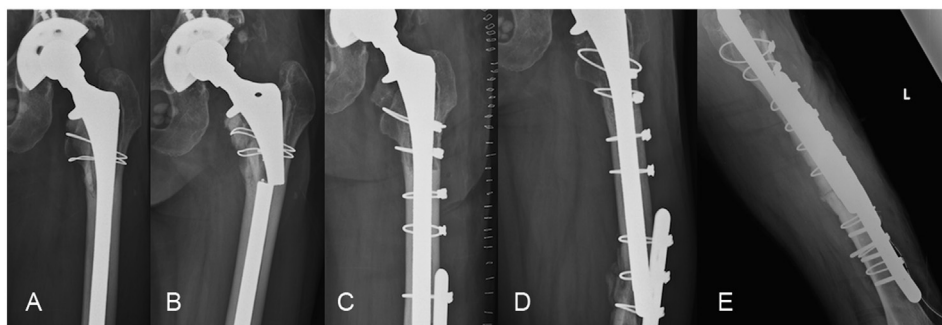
(A) The patient was a 50-year-old woman who previously undergone second stage noncemented revision THA in 2002 due to periprosthetic joint infection status post first stage Girdlestone operation and antibiotic cement spacer implantation. There was minor bone loss in the trochanteric area. (B) After 121 months following the revision, the patient presented with thigh pain of sudden onset that occurred during daily activity. Radiographs revealed a stem that had fractured transversely at the subtrochanteric level. (C) An anterior femoral cortical window was made to remove the distal well-fixed prosthetic segment, and revision surgery using a larger Versys long-stem was performed. A cable plate and wire were used for fixation of the osteotomy site. (D) During F/U, periprosthetic fracture over stem tip was noticed 4 weeks later. (E) Open reduction and internal fixation was performed with double plate. The fracture healed 6 months later after 3 months protected weight bearing.
